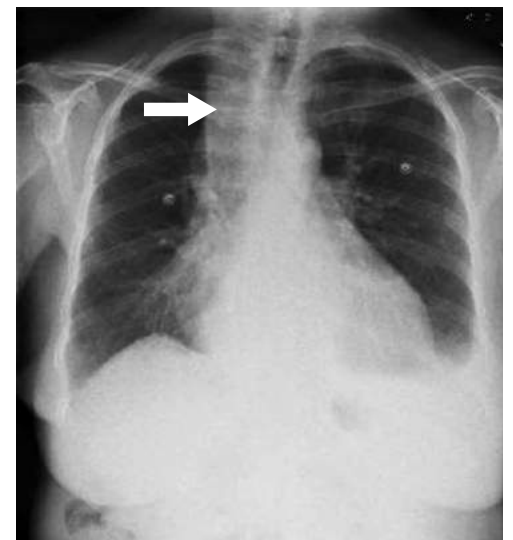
An anteroposterior radiograph shows right upper lobe consolidation (arrow).
